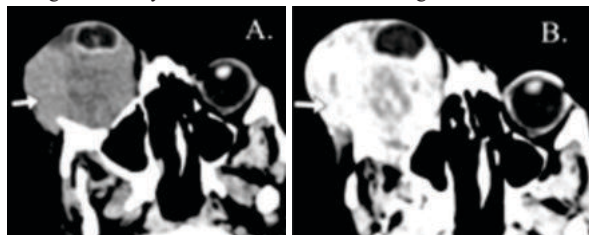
Embryonal Rhabdomyosarcoma. A 5years female child presented with right orbital swelling. CT plain axial (A) contrast-enhanced (B) images show ill-defined soft tissue density heterogeneously enhancing lesions in the right orbit and maxillary region involving the inferior rectus and inferior oblique muscle with proptosis.
